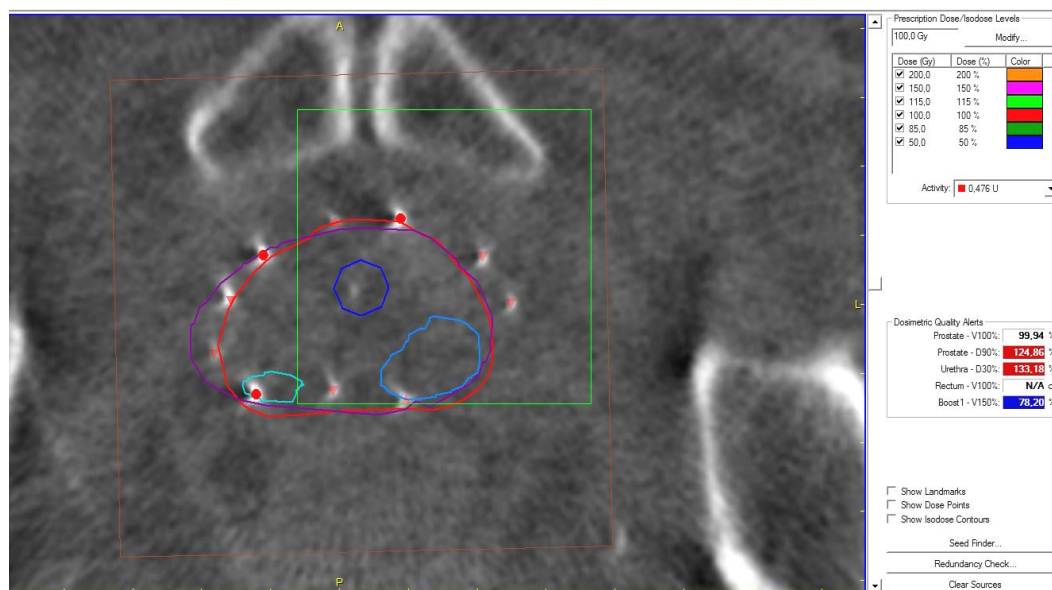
Contours from US and MRI transferred to CBCT for dosimetry of patient 7 in VariSeed. The prostate (red) and urethra (dark blue) were contoured on US-post, Prostate_{MRI} (purple), Boost₁ (light blue) and Boost₂ (turquoise) were contoured on T2 and the seeds (● and ▼) were localized on CT-post. Image blending is set to CT-post and the isodose lines are not shown.
